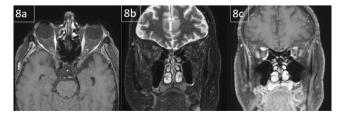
Magnetic resonance imaging at 3-month follow-up: Inflammation in the right orbital apex was attenuated in the axial fat-suppressed postrate T1-weighted (a), coronal fat-suppressed T2-weighted (b), and postcontrast coronal fat-suppressed T2-weighted sections (c). The overcrowded appearance was resolved and the optic nerve and surrounding structures could be clearly distinguished
